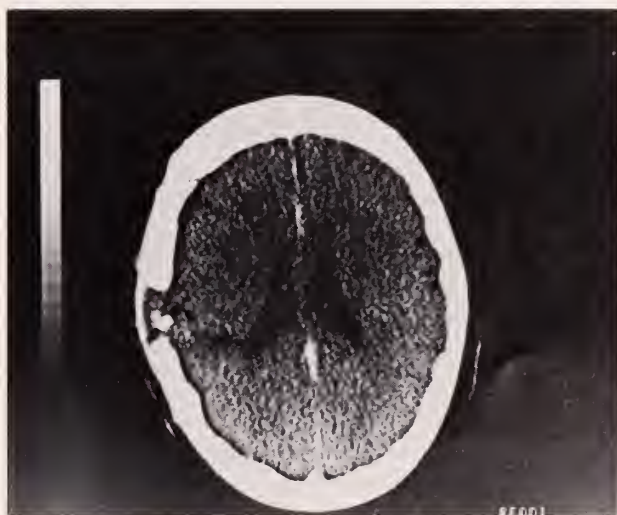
CT scan showing gross bony abnormality of the calvarium with intracranial extension and a soft tissue mass in the right parietal area.
